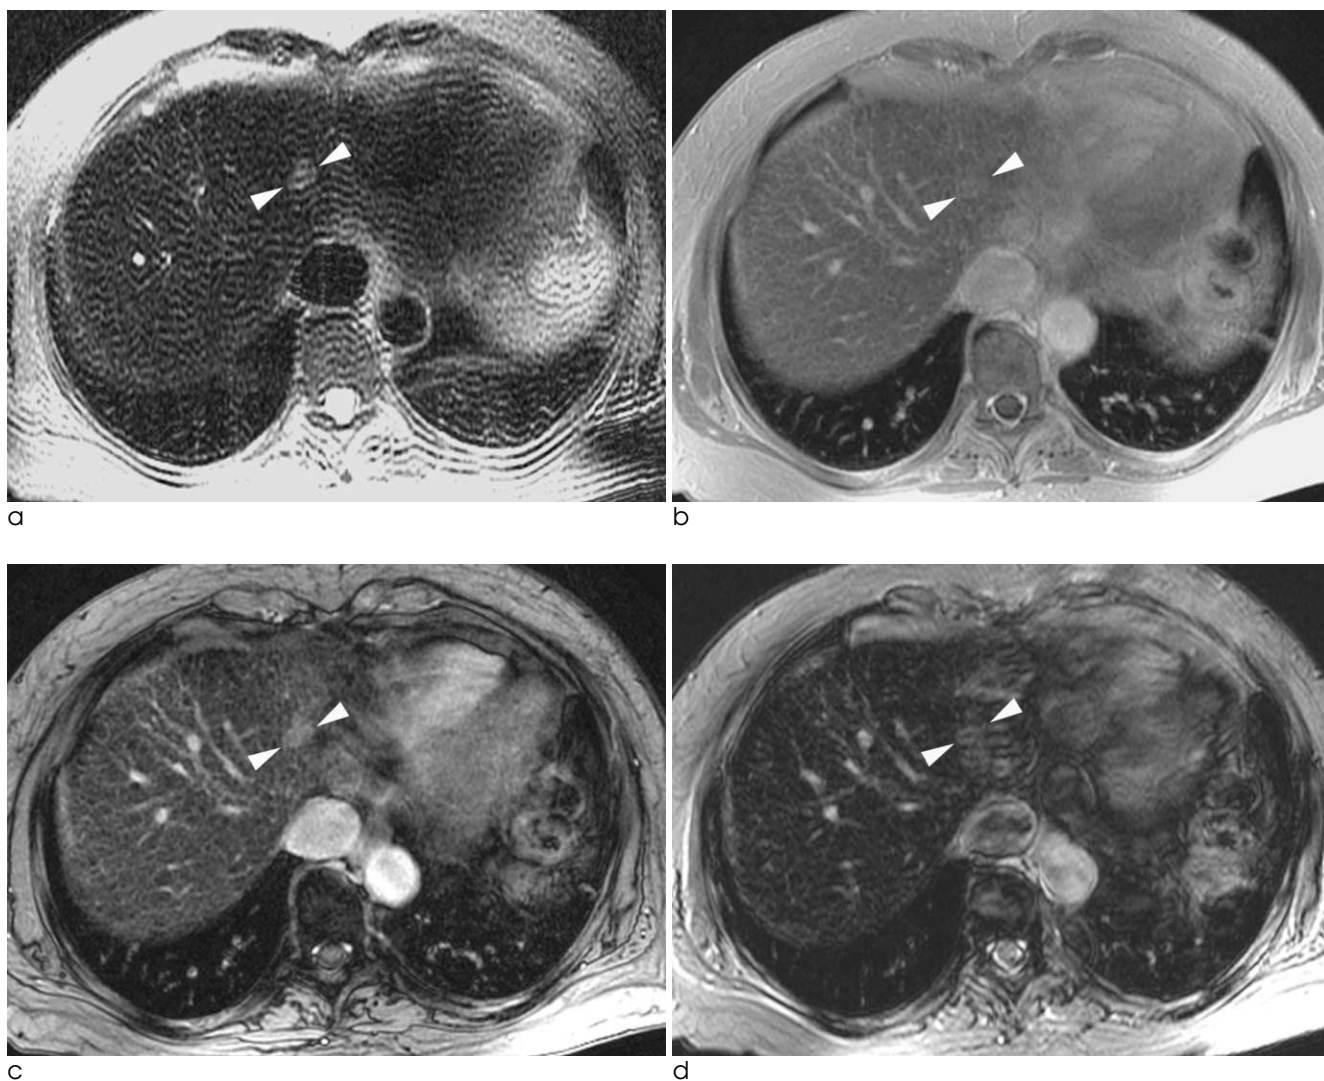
A 59-year-old woman with a hepatocellular carcinoma in the cirrhotic liver. Among the four difference MRI sequences of fast imaging after ferucarbotran injection, turbo spin-echo image (c) shows worst quality in hepatic contour, vascular landmark and overall imaging artifact compared to gradient echo images using a TE of 2.4 msec (b) or 5.8 msec (c). Due to the serious pulsation artifact, the small hepatocellular carcinoma (arrowheads) in left lobe of the liver is not well defined on gradient echo imaging using a TE of 10 msec (d).
